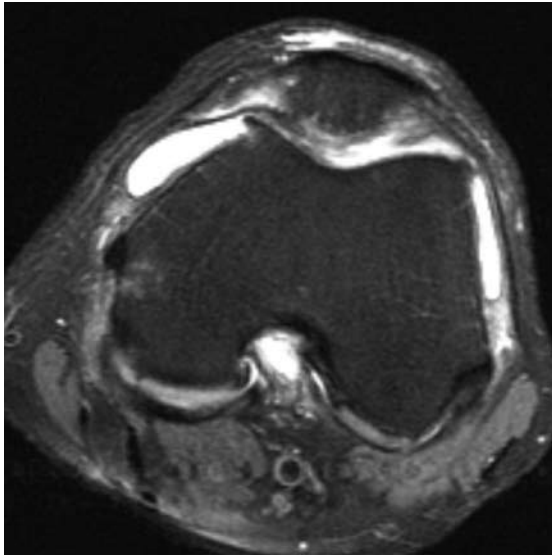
46-year-old man with persisting medial left knee pain. Axial TSE T2-W MR image shows a long mediopatellar plica extending to the posterior medial patellar facet and anterior aspect of the medial femoral condyle. There is associated bone marrow oedema in the lateral aspect of the patella, due to recurrent impingement.
